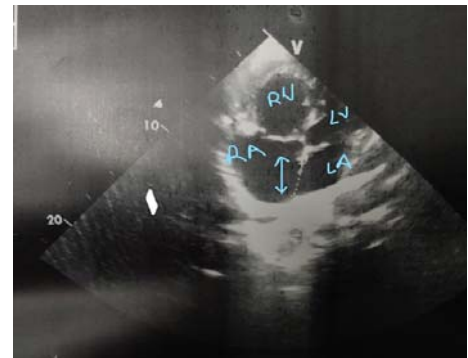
Echocardiography (4 chamber view) showing Ostium secundum type of ASD. The defect is shown with dotted line measuring 2.5mm
